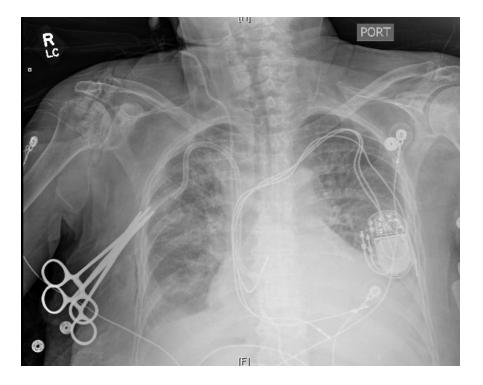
Pre-op portable chest x-ray
